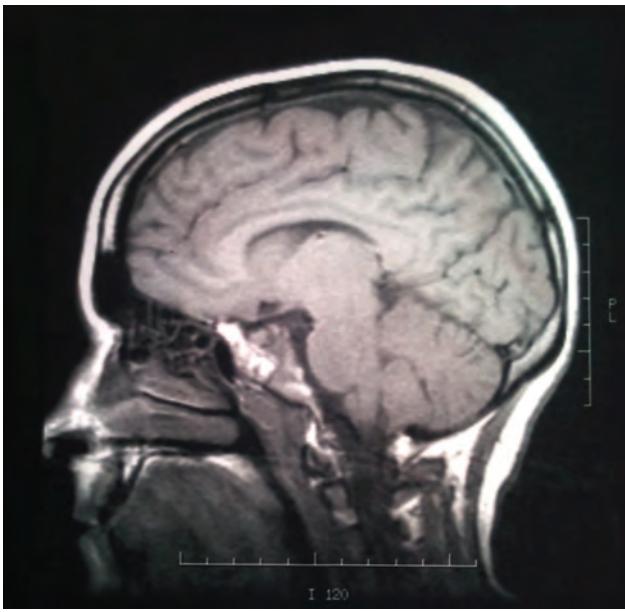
MRI image of the brain: Key brain structures can be observed in fine detail.
